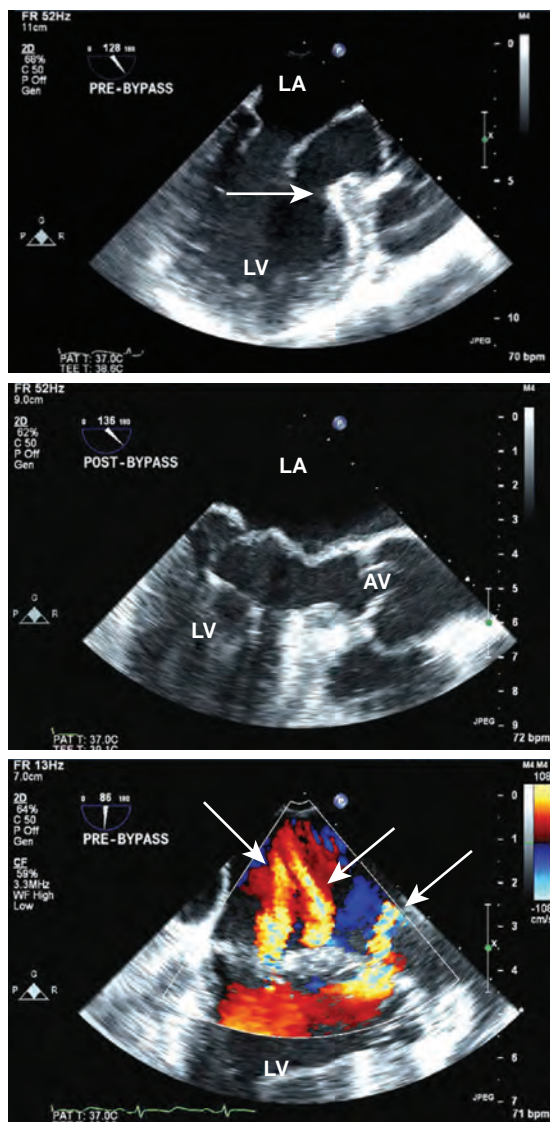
(Top panel) A transesophageal long-axis view shows the left ventricular outflow tract and depicts the hypertrophy of the basal portion of the interventricular septum (arrow). (Middle panel) A similar image during systole reveals bileaflet prolapse of the mitral valve. (Bottom panel) With color-Doppler imaging, at least three jets of mitral regurgitation (arrows) are noted. AV, Aortic valve; LA, left atrium; LV, left ventricle.
